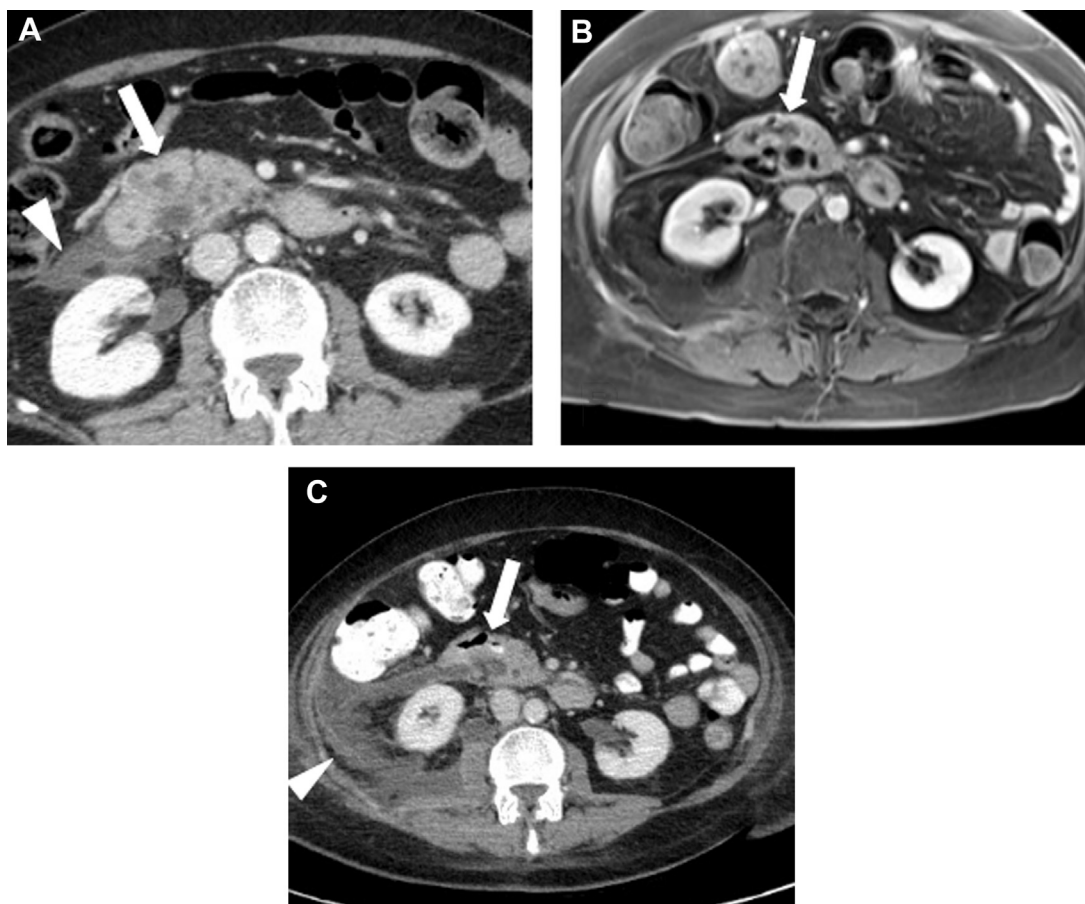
Periapillary duodenal diverticulum. A 70-year-old woman with elevated liver function tests. Axial CT (A) and MR (B) images, both performed with intravenous contrast, demonstrate a heterogeneous focus adjacent to the pancreas head (arrows) which was mistaken for a mass. (C) Image from subsequent oral and intravenous contrast-enhanced CT shows air and oral contrast at the same site (arrow), diagnostic of a duodenal diverticulum. Peripancreatic and right-sided retroperitoneal fluid (A, C [arrowheads]) is secondary to acute pancreatitis.
